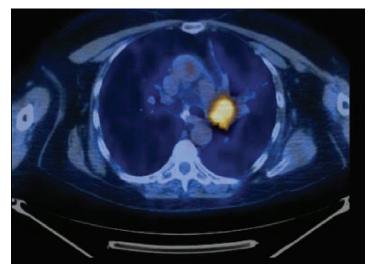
Positron emission tomography–computed tomography image revealing a 5.8 cm mass at the hilum of the left lung.
